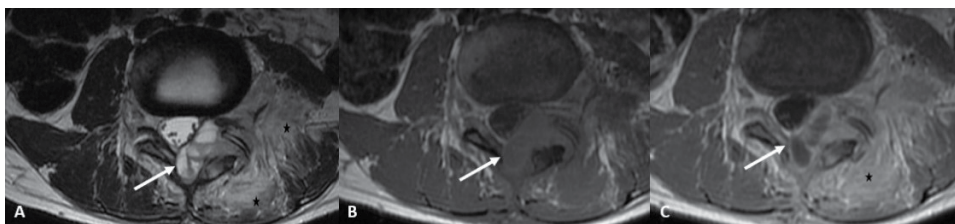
Osteoblastoma: Axial MR images of the lumbar spine shows an expansile mass lesion involving the left lamina and pedicle, encroaching in the spinal canal. It demonstrates heterogeneous hyperintense T2 signal (white arrow) with subtle fluid–fluid levels (A). The lesion shows an intermediate T1 signal (B) and shows heterogeneous enhancement as depicted in the T1-weighted post-contrast (C). The left posterior paraspinal muscles demonstrate hyperintense T2 signal and post-contrast enhancement (black asterisks).
